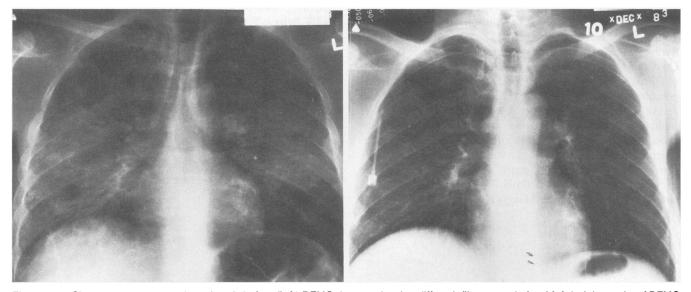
Chest roentgenograms in patient 2, before (left) DFMO therapy showing diffuse infiltrates and after (right) eight weeks of DFMO therapy showing near complete resolution of infiltrates.
